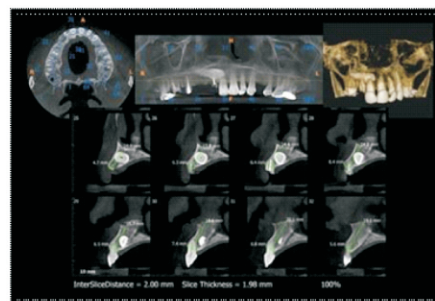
CBCT of patient
